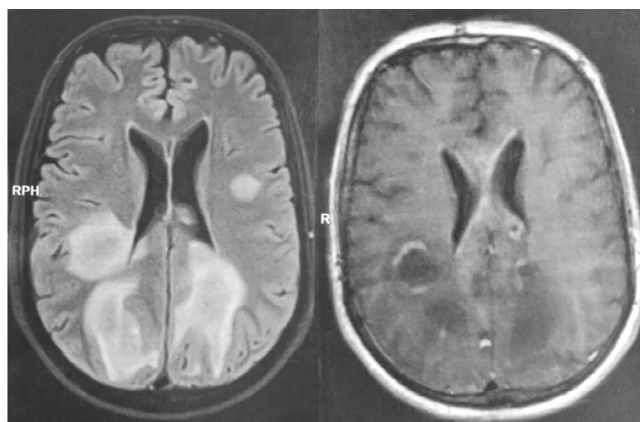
Brain magnetic resonance imaging (T1 GADO and Flair) showed multiple patchy and nodular lesions in the bilateral parieto-occipital regions, with ring enhancement after gadolinium injection
